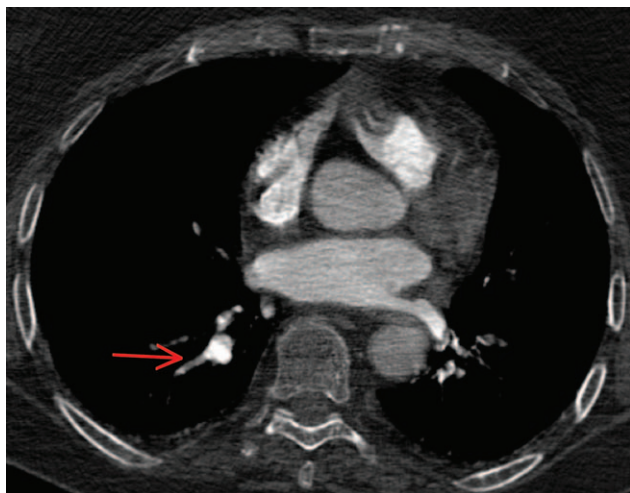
Axial CT pulmonary angiography showing segmental thromboembolism (red arrow) in the right lower lobe, with angiographic defect exhibiting the customary high-density appearance of thrombi in COVID-19 patients receiving low-molecular-weight heparin at prophylactic dosage. COVID-19=coronavirus disease 2019; CT=computed tomography.
